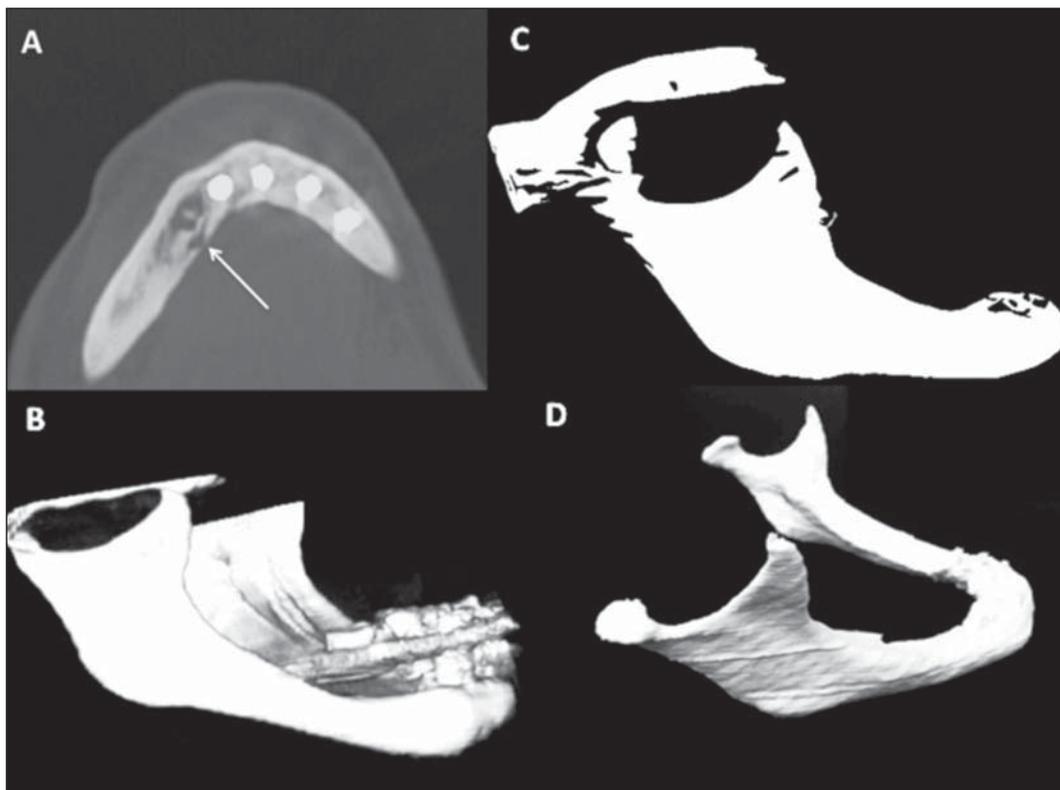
A: Axial computed tomography slice showing an osteolytic lesion in the right mandible (arrow). B: 3D volume-rendering computed tomography reconstruction of the mandible. C: 3D digital file, containing images of the mandible, being analyzed and processed in CAD software. D: Final aspect of the mandible prototype printed in 3D to mold the osteosynthesis material before surgery.
